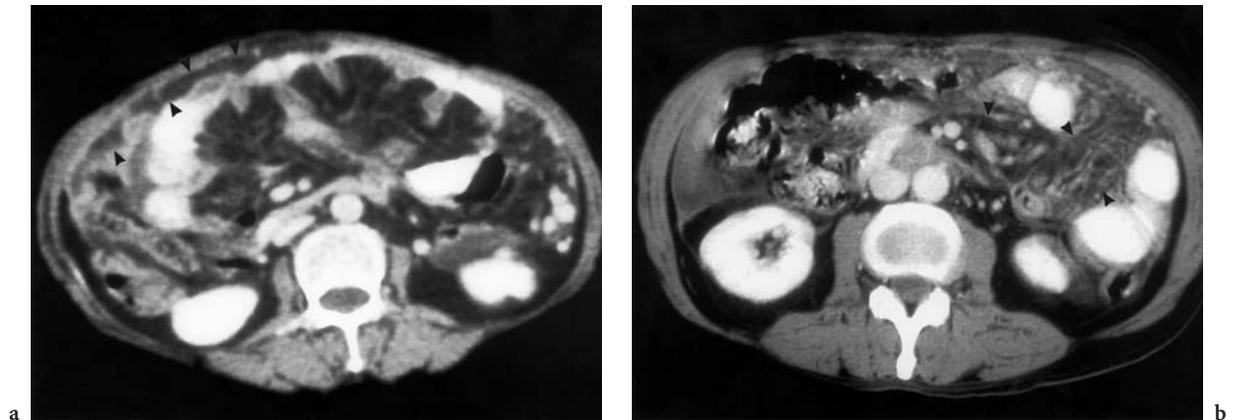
Tuberculous peritonitis. Computed tomography (CT) scans of two patients with documented tuberculous peritonitis. a Contrast-enhanced CT of abdomen shows thickening and fat infiltration of the omentum (omental plaque--arrowheads). b Contrast-enhanced CT of abdomen showing irregularity and fatty infiltration of the mesentery (arrowheads)
